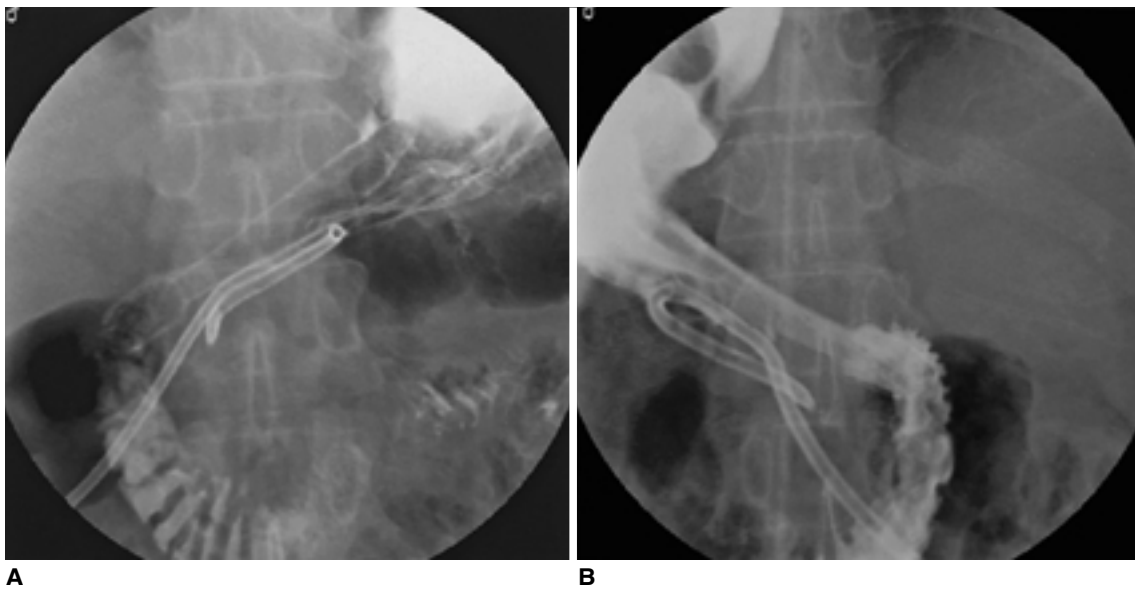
UGI radiographs after covered metallic stent placement show (A) fully expanded stent, and (B) good passage of contrast media.
